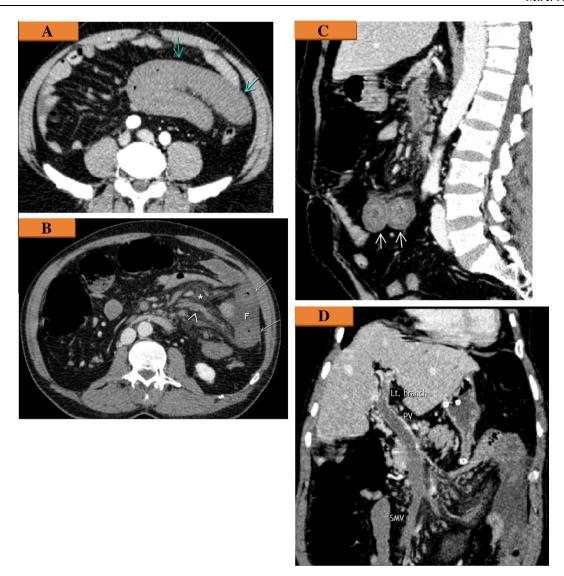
A 62 year old male patient presented with colicky abdominal pain with vomiting and constipation with history of splenectomy 15 years ago, axial CT scans (A and B) showed bowel wall thickening (arrows) and distension with no enhancement, mesenteric fat stranding, (\*), free fluid (F) and engorged venous collaterals (arrow head), sagittal reformatted contrast-enhanced image (C) showed target sign (arrows), portal phase curved coronal reformation (D) showed thrombosis of both superior mesenteric vein (SMV) and portal vein (PV).
